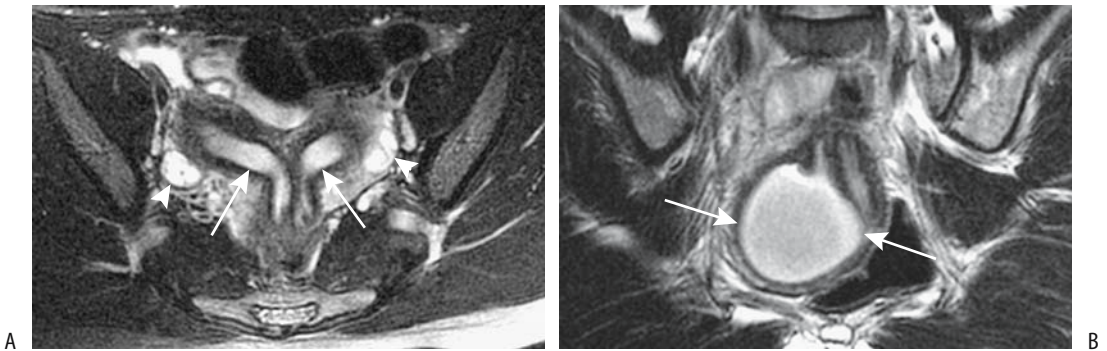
Uterus didelphys with obstructed hemivagina. A: Transverse T2-weighted MRI identifies two uteri (arrows), two cervixes, and both ovaries (arrowheads.) B: Coronal T2-weighted image shows a hematocoele (arrows) due to an obstructed right hemivagina. (Source: Imaoka I, Kitagaki H, Sugimura K. MR imaging associated with female infertility. *Nichi-Doku Iho* 2000;45:440–450, with permission from Nihon Schering K. K.)
